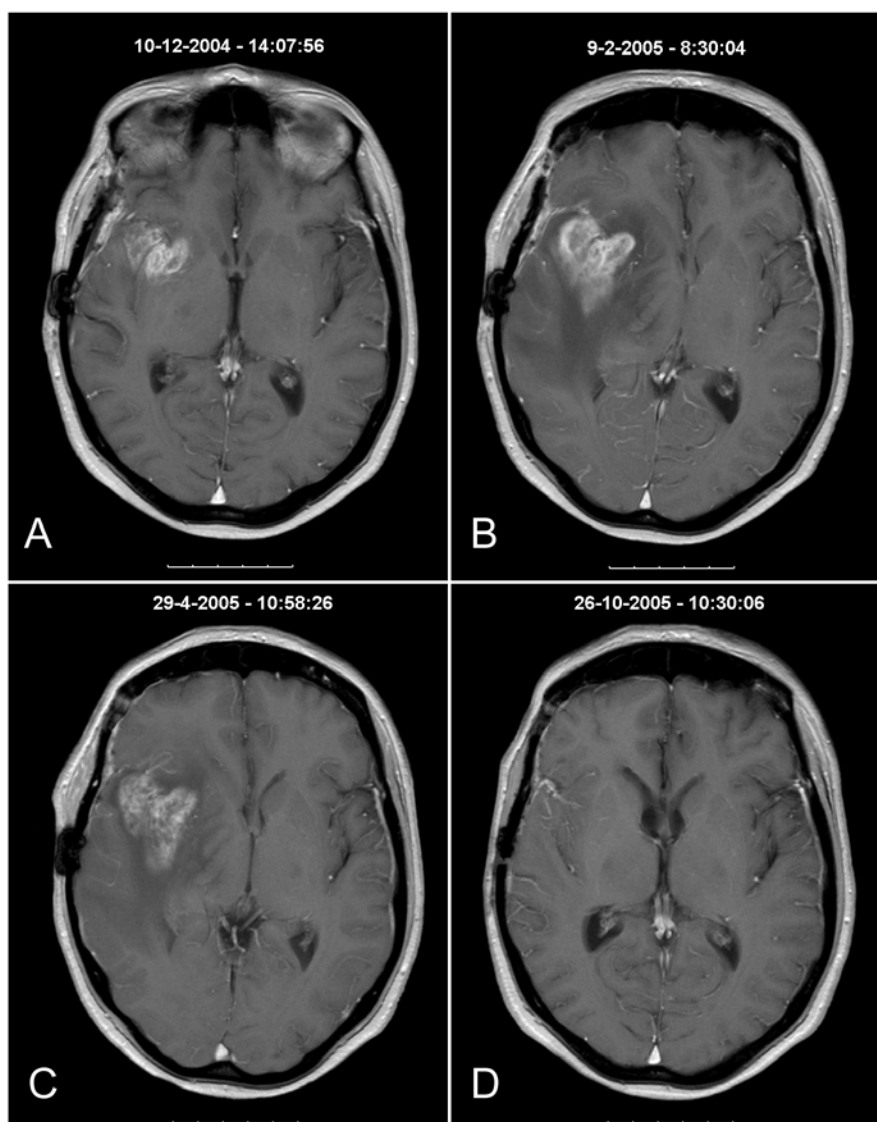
Patient 8: A 50-year-old female was diagnosed with a right temporal glioblastoma. Debulking surgery was followed by radiotherapy and concomitant temozolomide (RT/TMZ). Compared to the pre-RT/TMZ scan (A) the scan of the brain 4 weeks after RT/TMZ showed progression of the area of gadolinium uptake (B). She remained clinically stable and was on a stable dose of dexamethasone. She continued with 3 cycles of adjuvant TMZ and the dexamethasone was gradually lowered and stopped. The MRI scan 3 months after the RT/TMZ was unchanged (C) and she received another 3 cycles of TMZ. The MRI scans 6 and 9 months after RT/TMZ showed a diminishing lesion (D). She progressed 12 months after the RT/TMZ.
